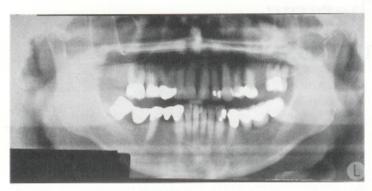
Panoramic radiograph showing apparent missing tooth roots of mandibular right distal bridge abutment.
